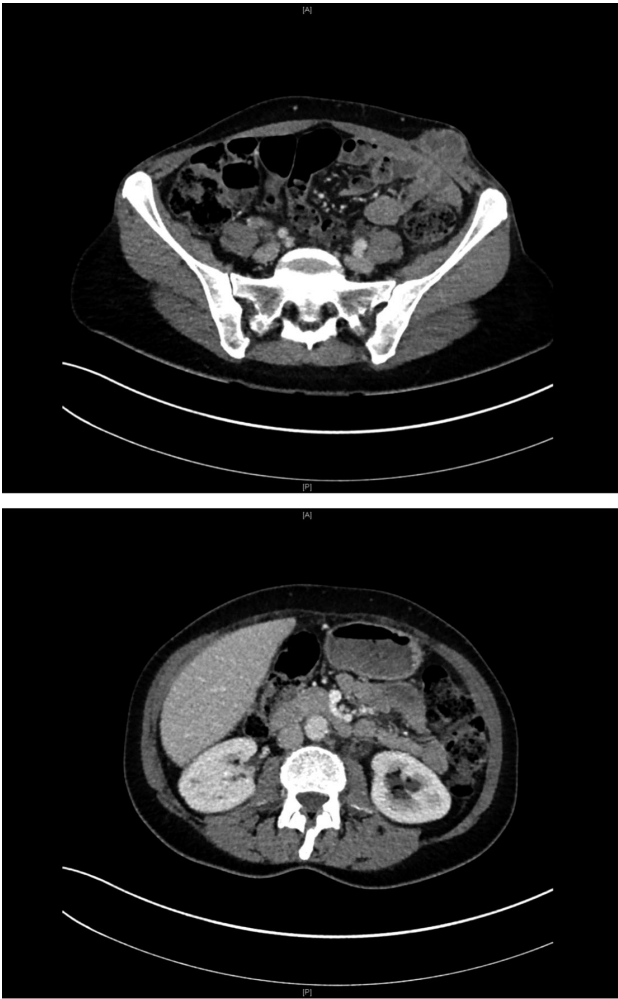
CT scan after completion of adjuvant chemotherapy.
